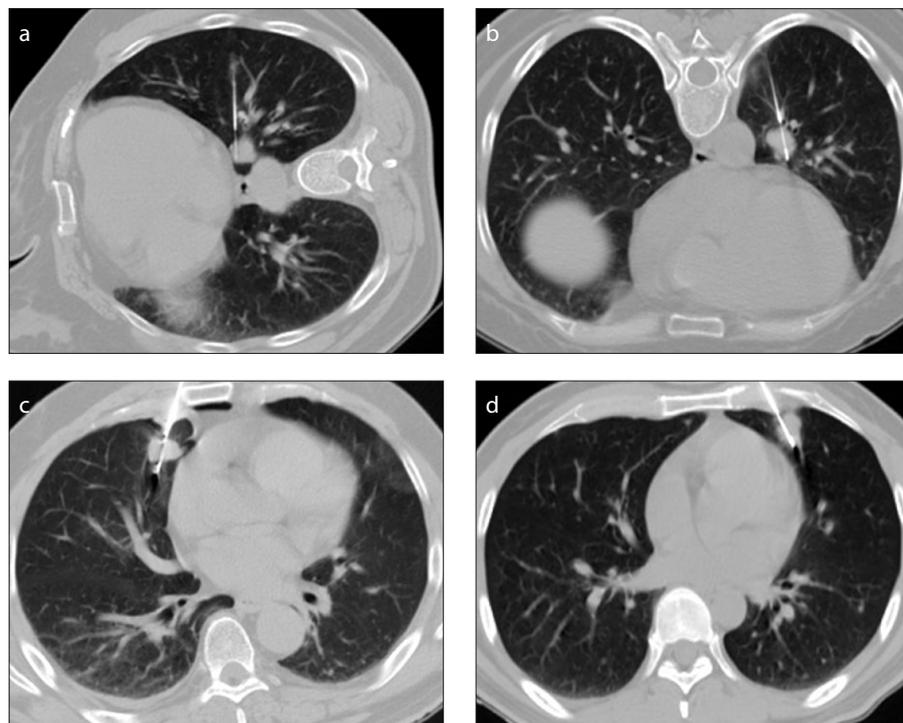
a–d. Representative CT images show lung nodules located within 10 mm of left atrium (a), left ventricle (b), right atrium (c), and right ventricle (d).
